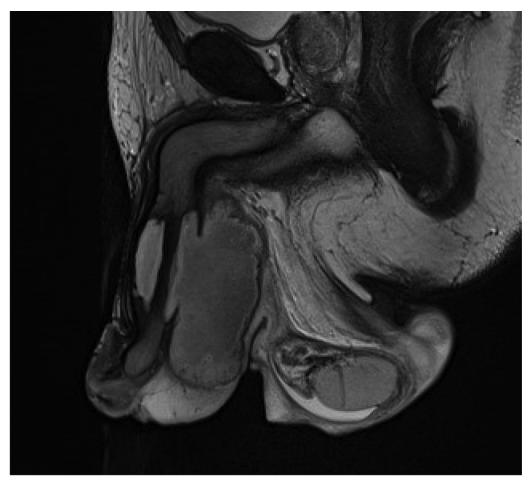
Magnetic Resonance Imaging. Sagittal view of penis/pelvis.
